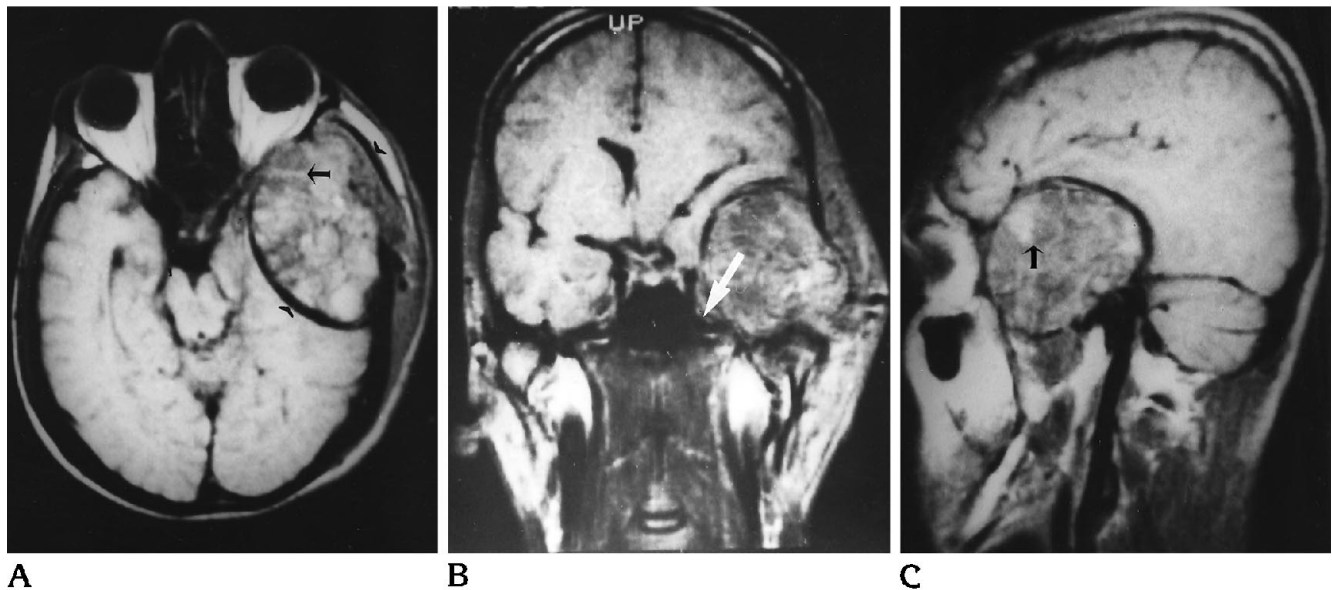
T1-weighted (650/22/2) spin-echo MR images.
